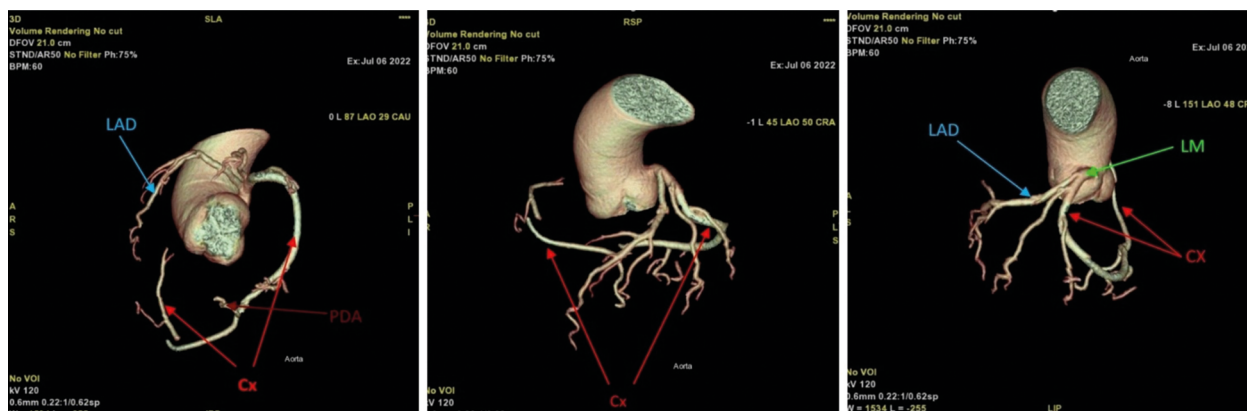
Computed tomography – volumetric reconstruction images
